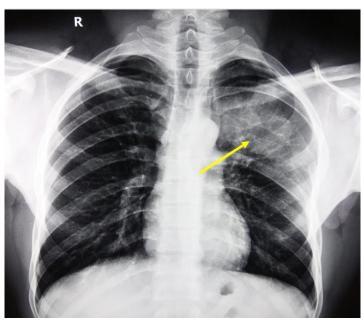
Chest X-ray showed in-homogenous opacification of left upper and middle zone
